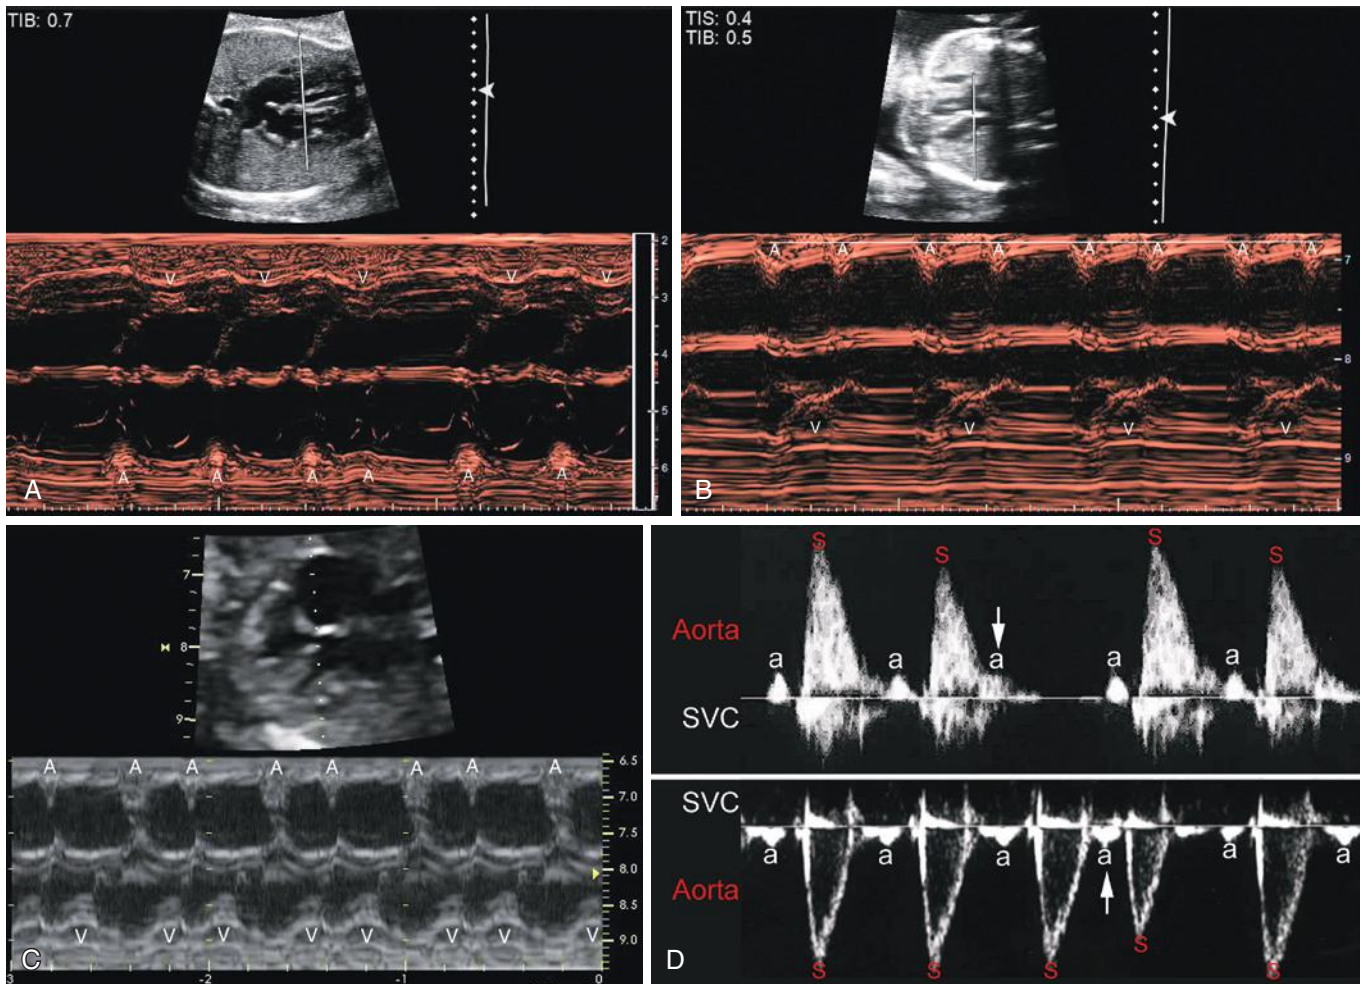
Premature atrial contractions. A, M-mode through the ventricles (*above*) and atria (*below*) during a single premature atrial contraction that is not conducted (A, atrial contraction; V, ventricular contraction). The fourth atrial contraction is premature and is not followed by a ventricular contraction. B, Blocked atrial bigeminy. M-mode through the ventricles (*below*) and atria (*above*). Every other atrial contraction is early; the premature contractions are not followed by a ventricular contraction. C, Conducted atrial bigeminy. M-mode through the ventricles (*below*) and atria (*above*); the premature contractions are always followed by a ventricular contraction. D, Premature atrial contractions. Simultaneous Doppler tracing of the superior vena cava (SVC) and ascending aorta showing isolated blocked (*upper panel*) and conducted (*lower panel*) premature atrial contractions (arrows). a, atrial contraction; s, ventricular contraction.
